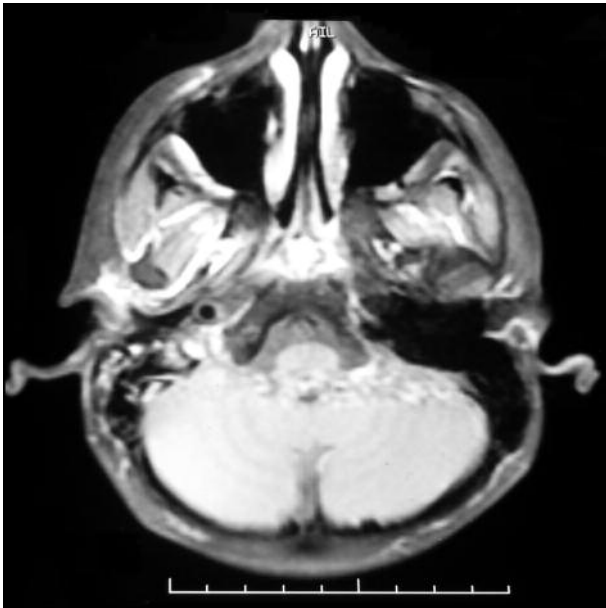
Contrast-enhanced fat-suppressed axial T1-weighted image shows focal area of enhancement along the right mastoid cells and right temporal bone
